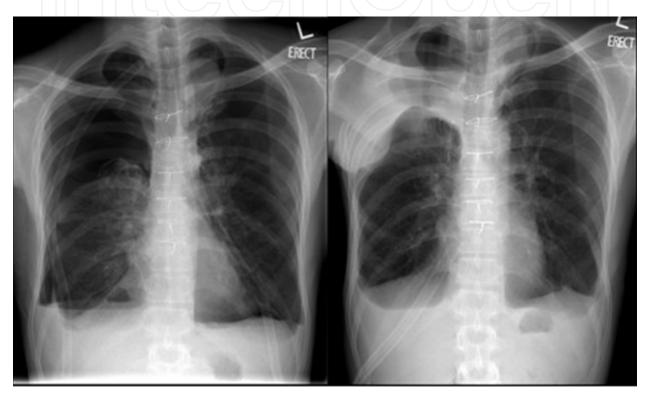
Pre-operative chest x-ray (left) showing a large potential pleural space with resulting persistent air leak in this patient who had underwent bilateral lung volume reduction surgery, and post-operative chest x-ray (right) showing effective re-expansion of the right lung after the placement of the latissimus dorsi flap.
